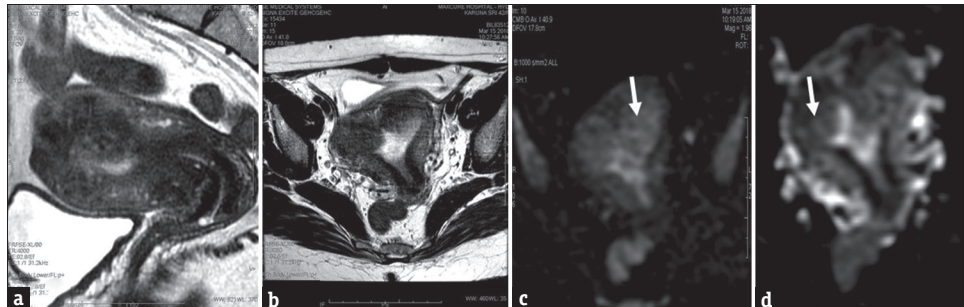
(a) Sagittal T2- and (b) axial T2-weighted images show submucosal mass projecting into the cavity with hyperintense small cystic components (yellow arrows). (c) diffusion-weighted image and (d) apparent diffusion coefficient show T2 dark phenomenon with projection of junctional zone into the endometrial cavity with nodular morphology and ill-defined borders (white arrows): polypoid adenomyoma
